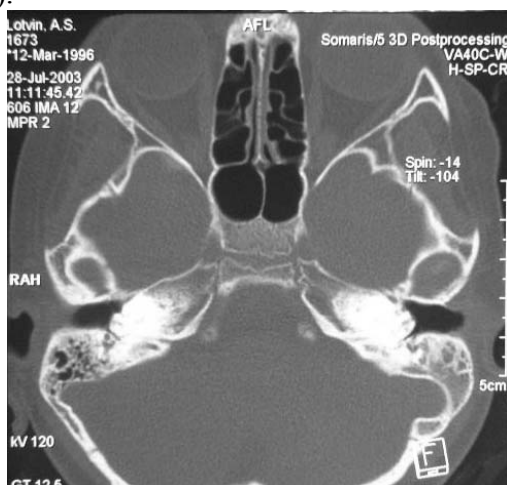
CT scans 8 years old girl with bilateral inner ear aplasia.
